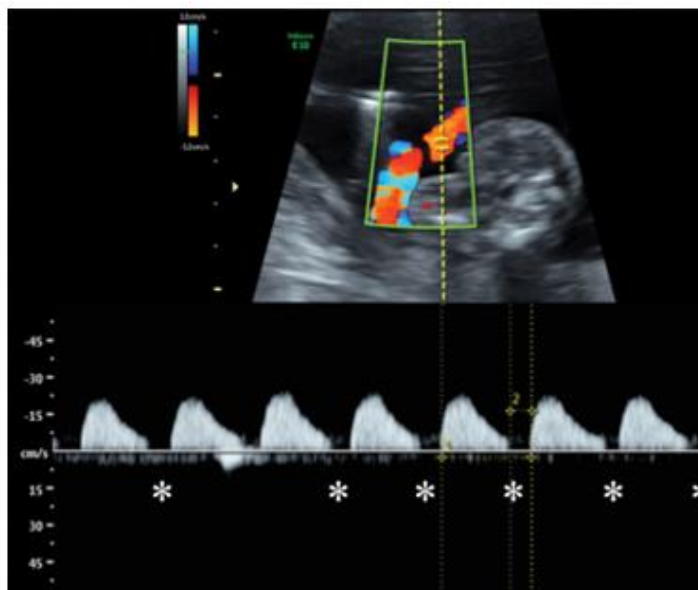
Showing Color Doppler sonography spectrum of umbilical artery in second trimester demonstrating end diastolic flow absence.
